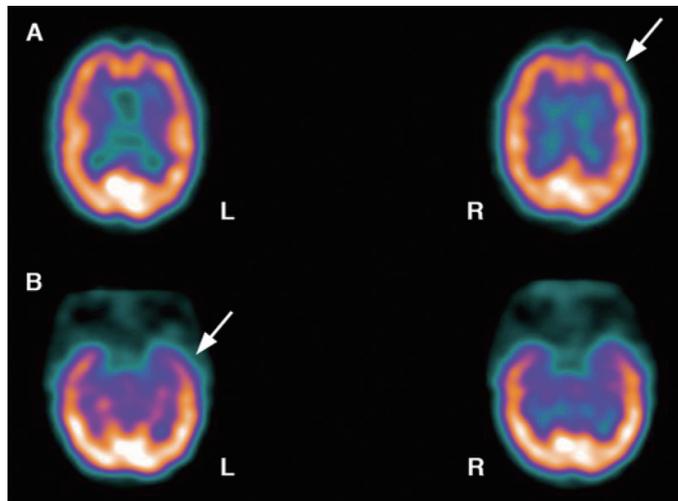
99m-Tc-ECD-SPECT evidenced hypoperfusion in the lateral frontal regions (A) and in the surface and mesial temporal lobes, especially in the left side (B).
